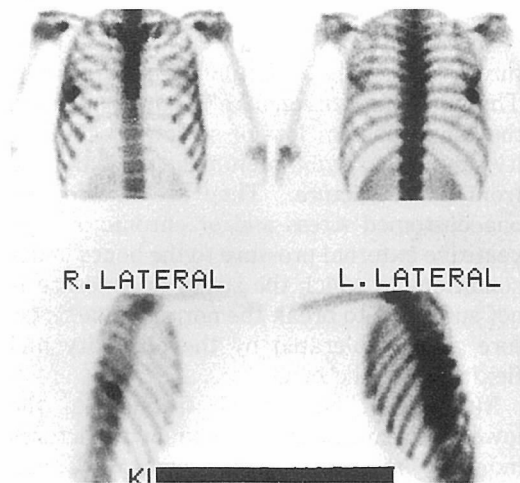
Bone scintigraphy performed 4 days later showing intense accumulation at the VIIIth rib. Lateral views revealed that the lesion was located at the posterior axillary line.
